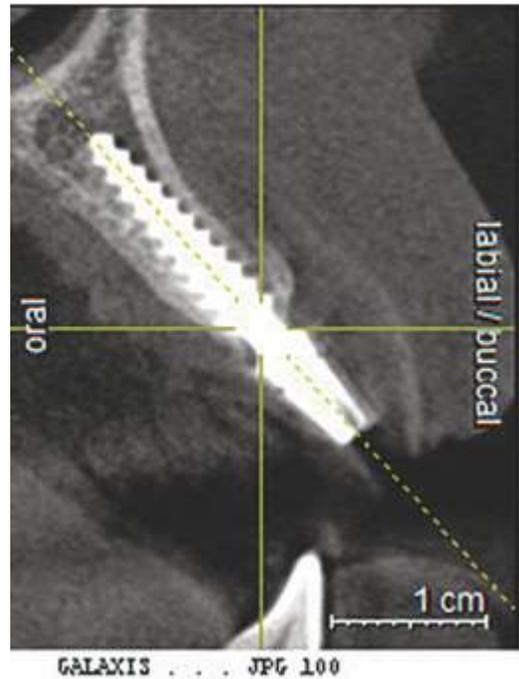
Post op CBCT [Rt]
